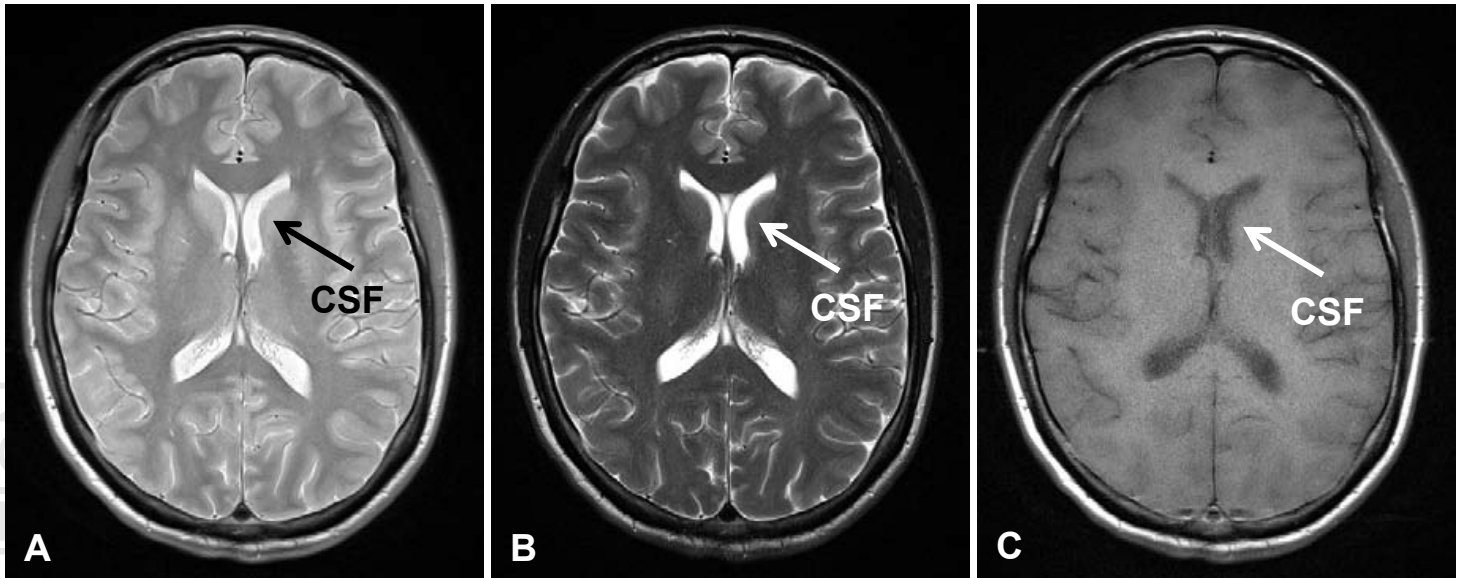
MRI of the brain. (A) Proton density-weighted axial image (TR = 4500ms, TE = 13ms). (B) T2-weighted axial image (TR = 4500ms, TE = 113ms). (C) T1-weighted axial image (TR = 600ms, TE = 13ms).
